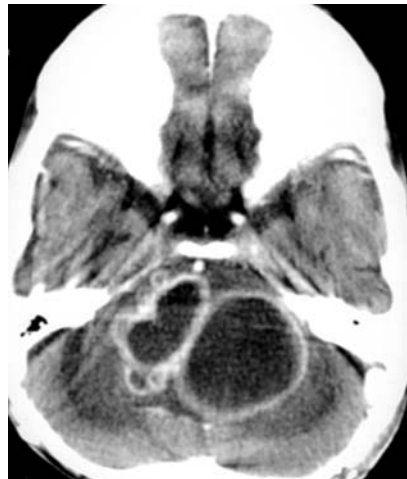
Post contrast CT scan in axial plane showing multilobular tuberculoma involving pons and cerebellum
